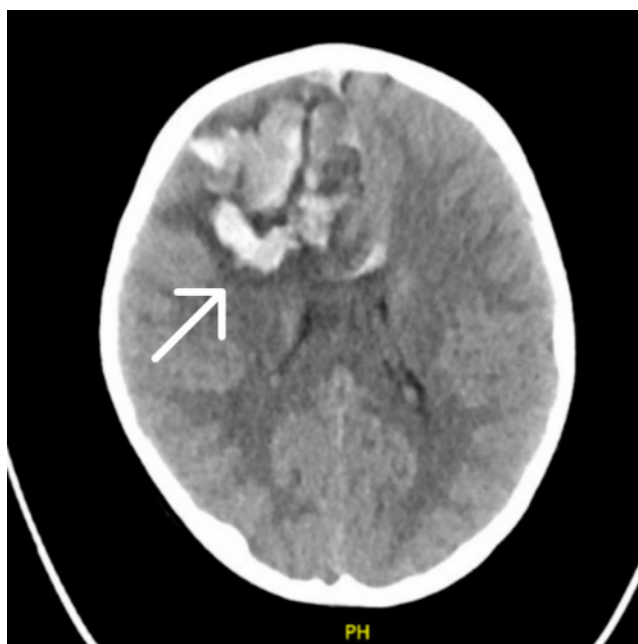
Head CT without contrast showing progression of haemorrhagic lesions
